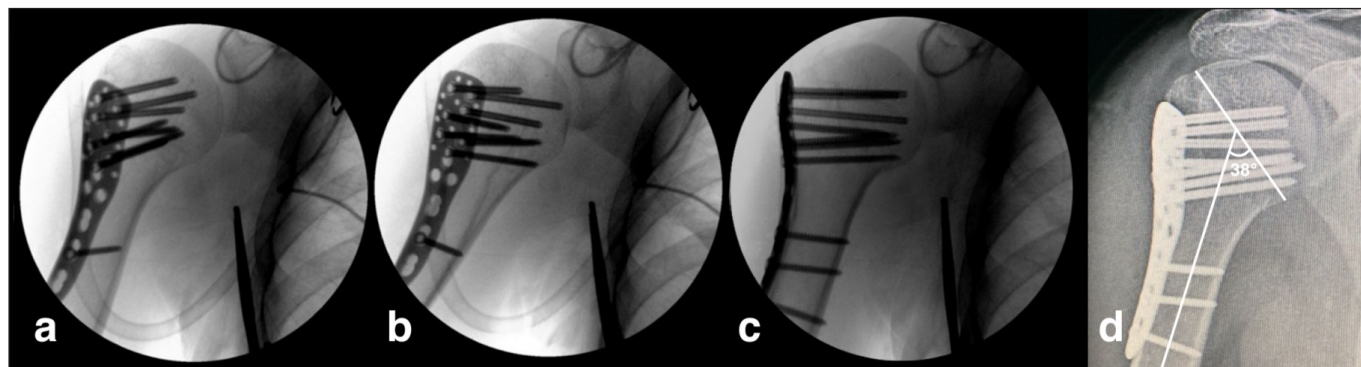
Internally (a), externally (b) and neutral (c) rotation fluoroscopy views of proximal humerus end of the operation. 1- year postoperatively radiograph is shown with 142 degrees of neck-shaft angle (d).
